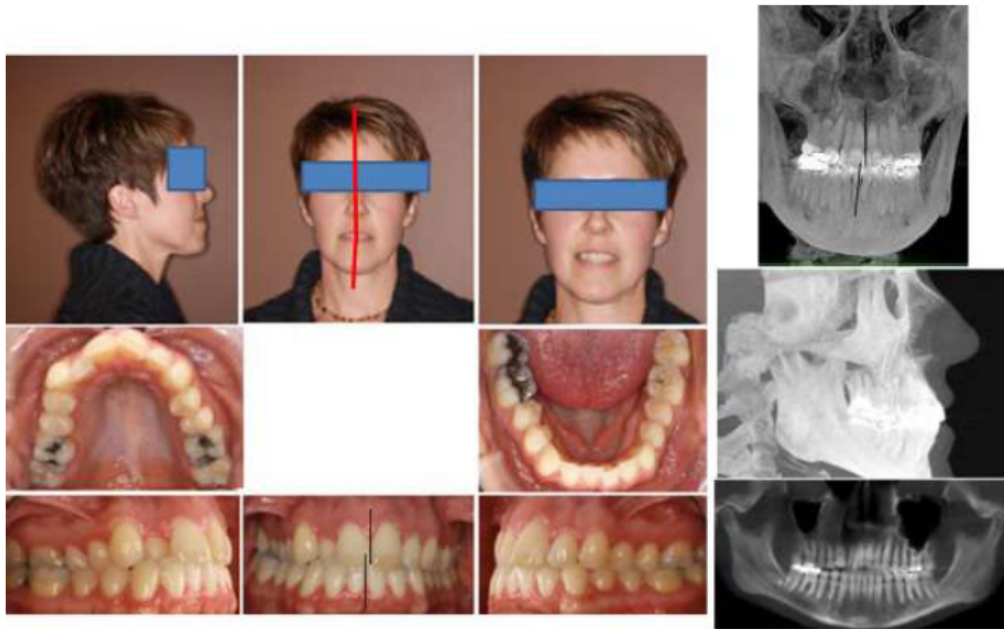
Initial clinical records of the patient with facial asymmetry. CBCT generated frontal cephalometric radiograph showing shift of the chin to the patient's right side.
